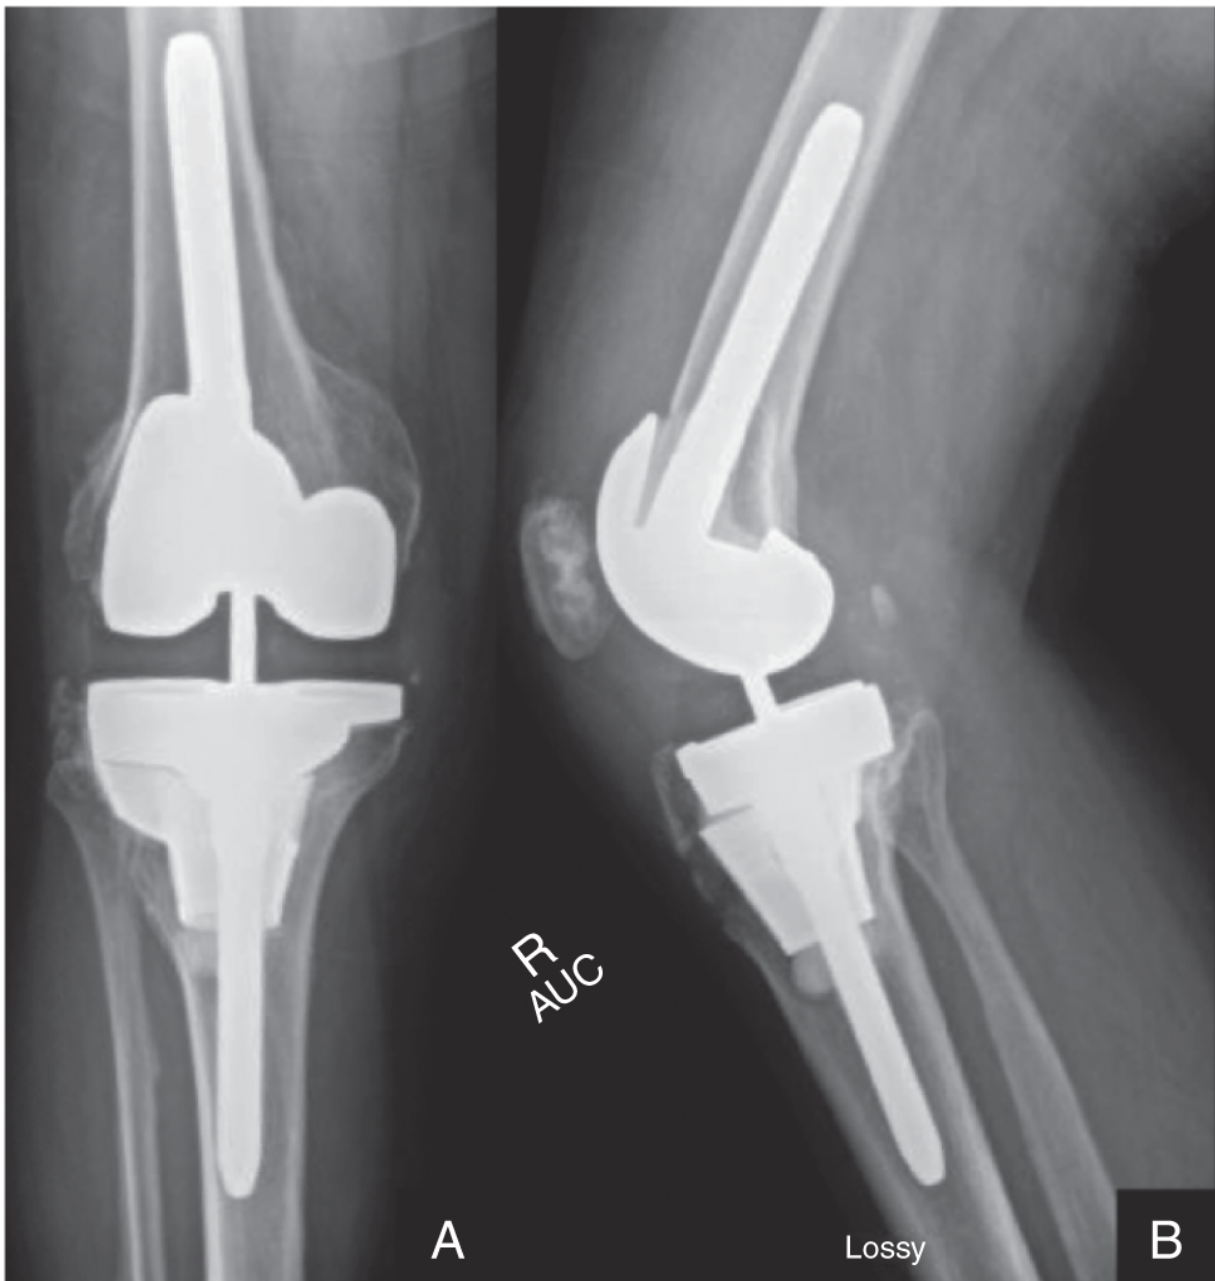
Radiographs at two-year follow-up.
